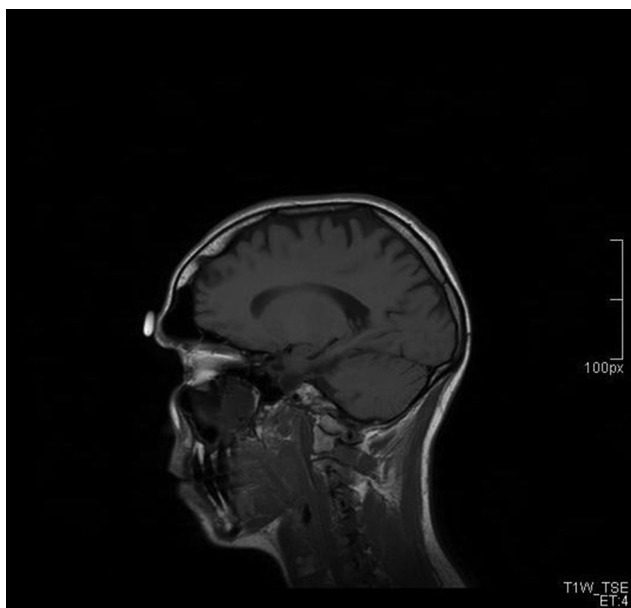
MRI Sagittal view. Pneumatized frontal sinus left. Normal aspect of cutaneous and subcutaneous tissue.
